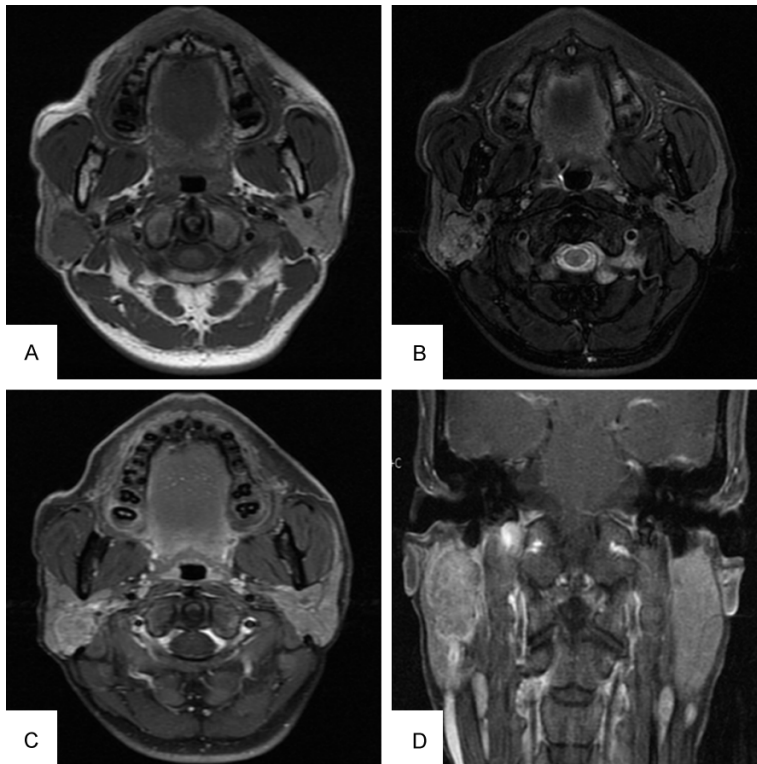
MRI of a 36-year-old man with MASC. (A) Non-enhanced T1-weighted sequences demonstrate an incompletely encapsulated mass in the right parotid gland. The mass is hypointense relative to the parotid gland. (B) T2-weighted fat-saturated sequences show a mass with mild hyperintensity relative to the parotid gland. (C) and (D) Axial (C) and coronal (D) contrast-enhanced T1-weighted sequences demonstrate a mass with heterogeneous enhancement, a ring-like enhancing margin, and no obvious necrosis.
